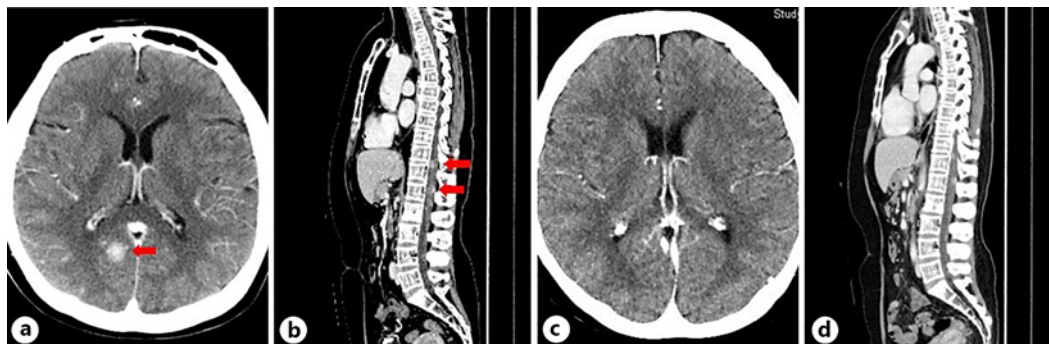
Contrast CT. a A tumor with contrast effect was found in the right occipital lobe, and BM was confirmed on CT before gamma knife therapy and T-DXd administration (red arrows). b The spinal cord at the level of thoracic vertebra 12, lumbar vertebra 1, and lumbar vertebra 4 showed areas of contrasted lesions, and spinal metastasis was confirmed on contrasted CT before gamma knife therapy and T-DXd administration (red arrows). c CT scan at 10 months after the commencement of T-DXd shows shrinkage of the BMs and edematous changes in the surrounding tissues. d On CT scan obtained 10 months after the commencement of T-DXd, spinal cord metastases are difficult to detect. CT, computed tomography; T-DXd, trastuzumab deruxtecan.
